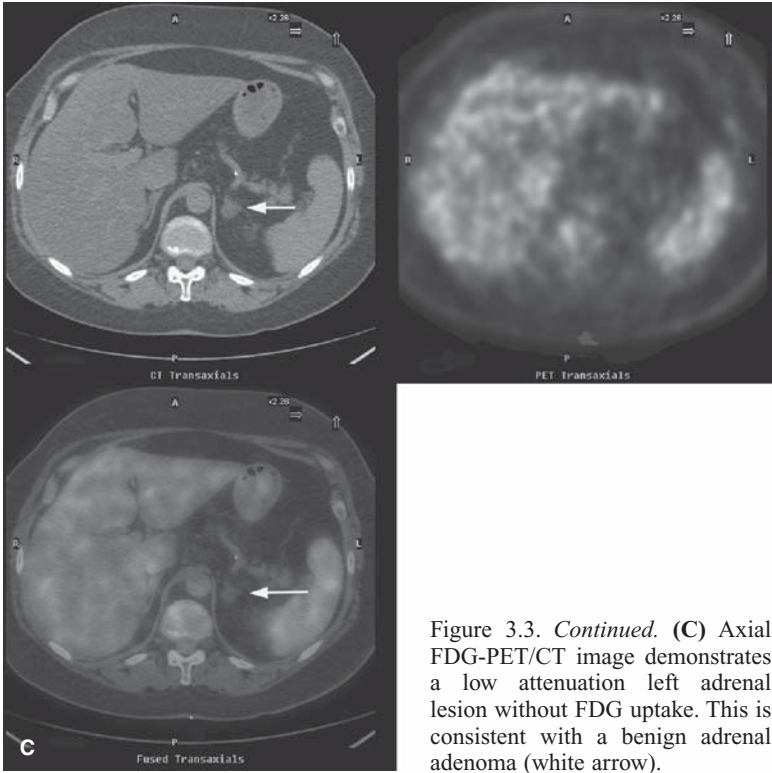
Continued.* (C) Axial FDG-PET/CT image demonstrates a low attenuation left adrenal lesion without FDG uptake. This is consistent with a benign adrenal adenoma (white arrow).
